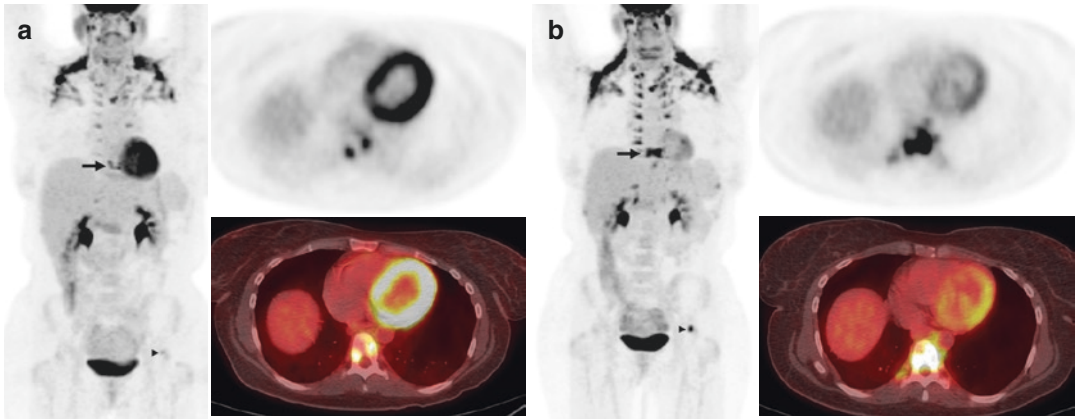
Classical Hodgkin lymphoma. (a) Baseline FDG-PET/CT showed abnormal FDG uptake in a mid-thoracic vertebra (SUVmax 5, arrow) and the left proximal femur (SUVmax 3, arrowhead) representing metabolically active lymphoma. (b) FDG-PET/CT scan 12 weeks after starting nivolumab showed increasing
